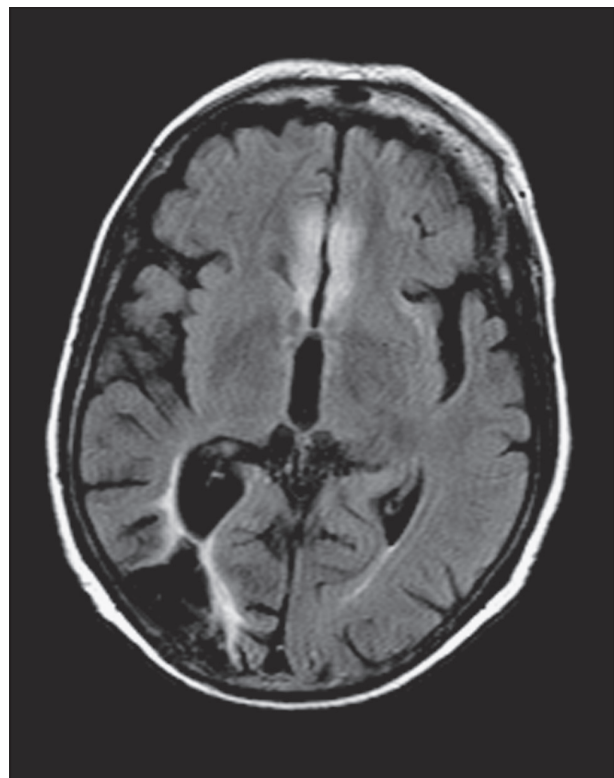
Cortico-subcortical zone of altered signal in pre-frontal and limbic gyrus of both sides and a previous ischaemic infarction with cavitation in the right parieto-occipital region (FLAIR).
